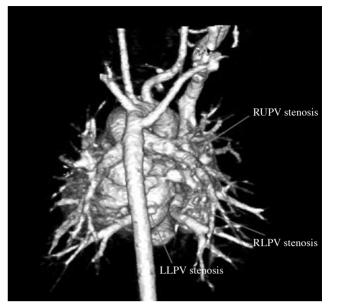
Pulmonary vein stenosis at postoperative three months. A computed tomography angiography image (posterior view). RUPV: Right upper pulmonary vein; RLPV: Right lower pulmonary vein; LLPV: Left lower pulmonary vein.
